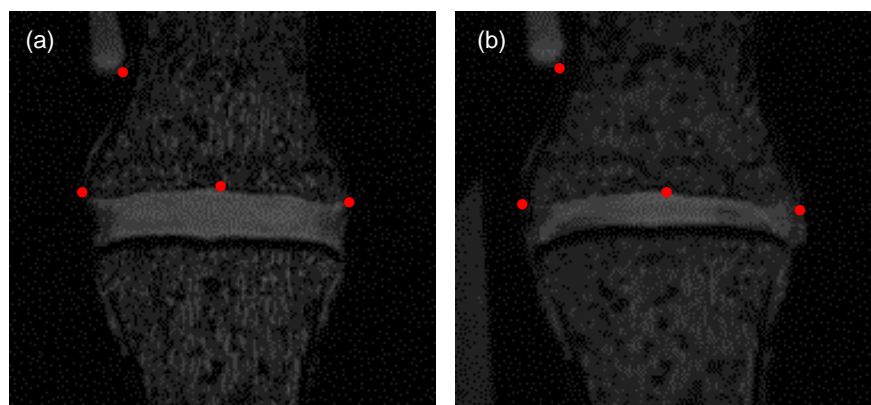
Sample MR images in the (a) prior to loading and (b) loaded state. The red dots indicate common points on the marker and superior EP that were used during the image registration process.
